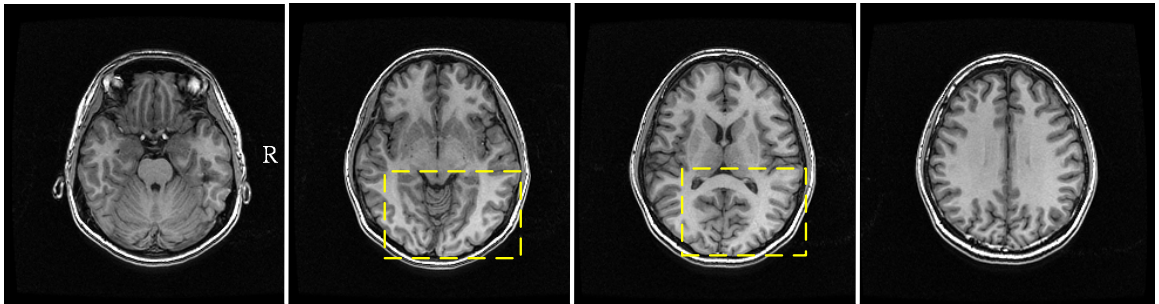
Intensity inhomogeneity of T1-weighted MR image. The right-posterior tissues highlighted in dashed boxes show obviously higher intensity compared to other regions.
